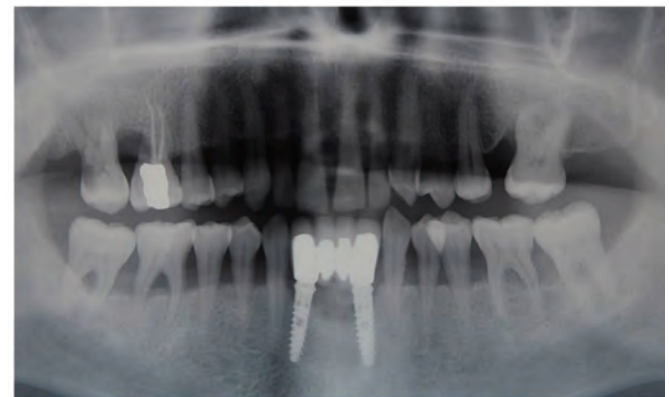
Radiographic view nine months after therapy.
